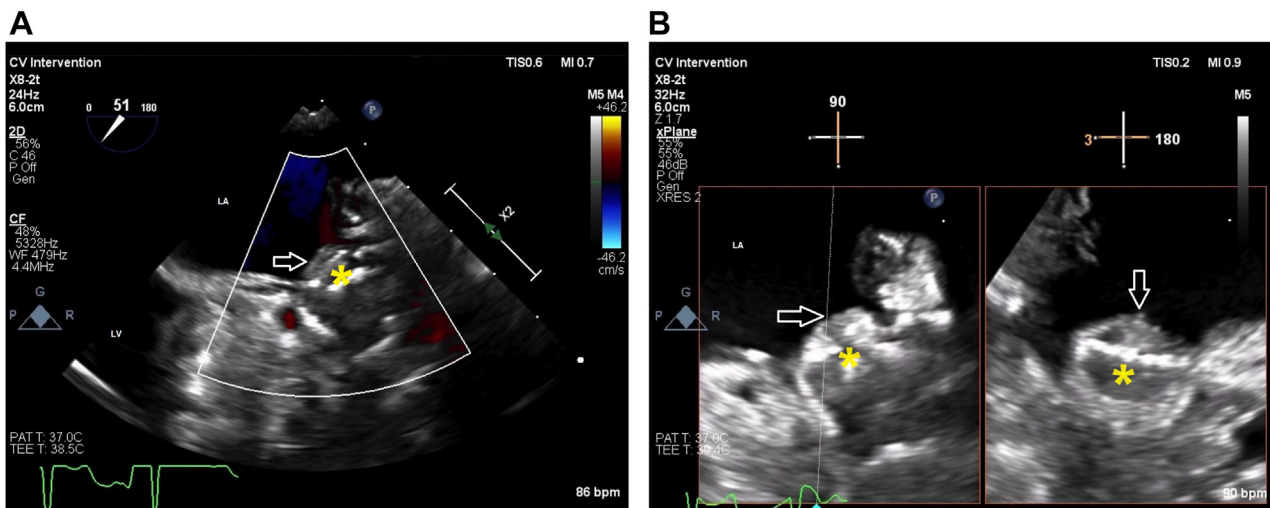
(A) Two-dimensional TEE performed after the embolic event, midesophageal (51°) view with color flow Doppler during diastole, demonstrates the LAAO device in LAA (asterisk) with a layered thrombus on the atrial surface (arrow) and no peridevice leak. (B) Zoomed, two-dimensional TEE, midesophageal orthogonal biplane (90° and 180°) views during systole, demonstrates the LAAO device in the LAA (asterisk) with a layered thrombus on the atrial surface (arrows).
